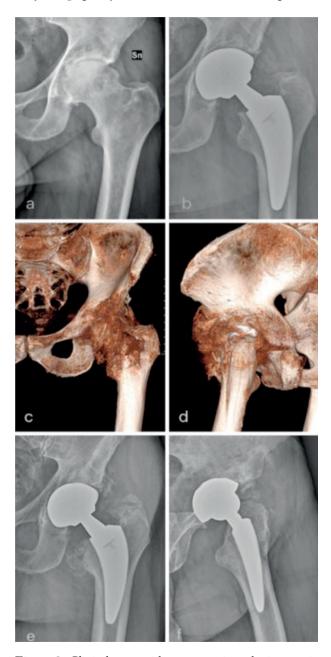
Clinical case with severe periprosthetic ectopic ossifications which required revision surgery: (a) preoperative x-ray; (b) postoperative x-ray at 1 month after THA; (c, d) 3D CT scan, anterior and posterior views respectively, of Brooker's grade 4 ectopic ossifications; (e, f) post-operative x-ray image after surgical removal of ectopic bone formations.
